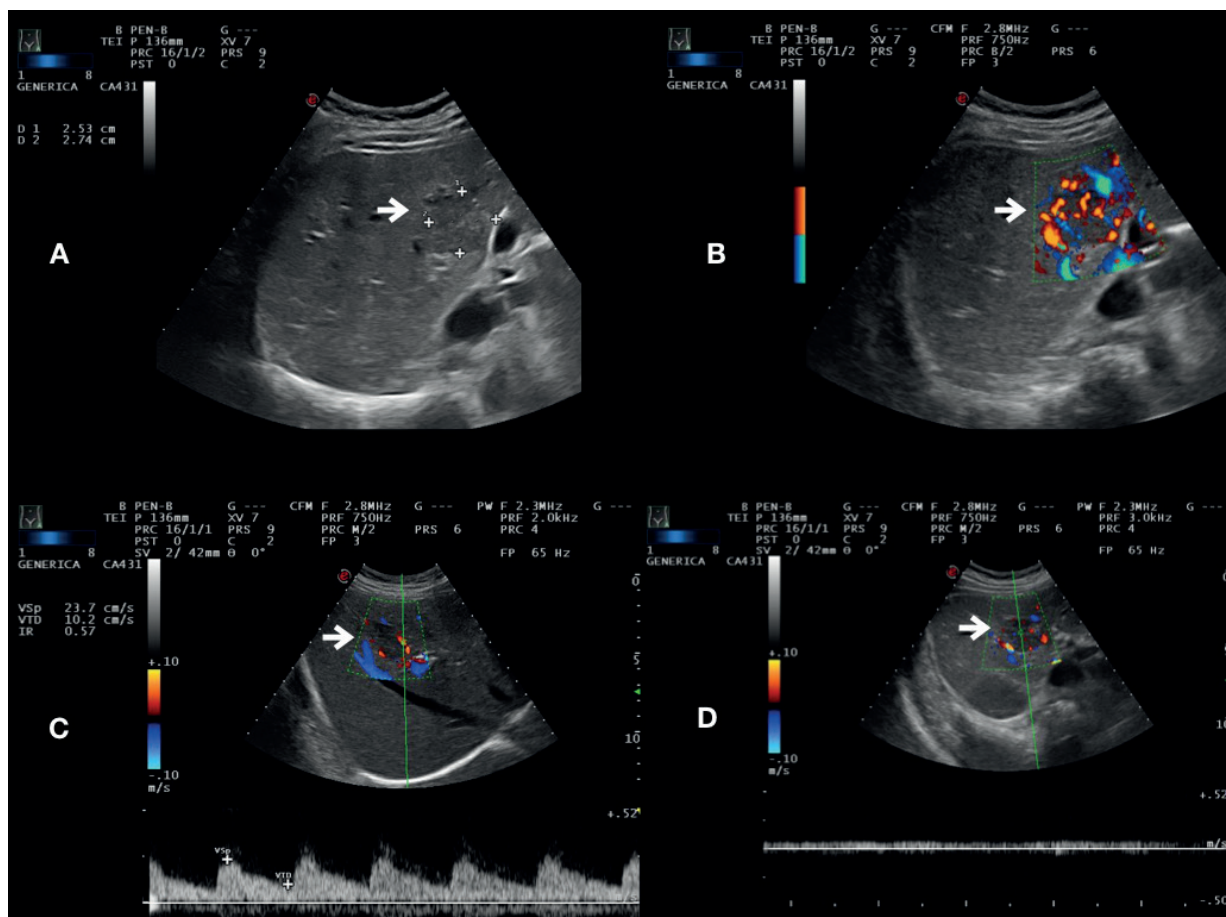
A 32 years old woman with a 2.5 cm FNH nodule of the segments VIII studied by conventional ultrasound (panel A), color (panel B) and pulsed wave Doppler analysis (panels C and D). Panel A, Hypoechoic lesion at B mode US. Panel B, color Doppler evaluation shows an intratumoral flow with the typical arterial spectrum characterized by the spoke-wheel sign. Panel C, pulsed wave Doppler analysis shows an arterial flow with low resistivity index. Panel D, pulsed wave Doppler analysis shows the presence of a central venous flow inside of the lesion.
